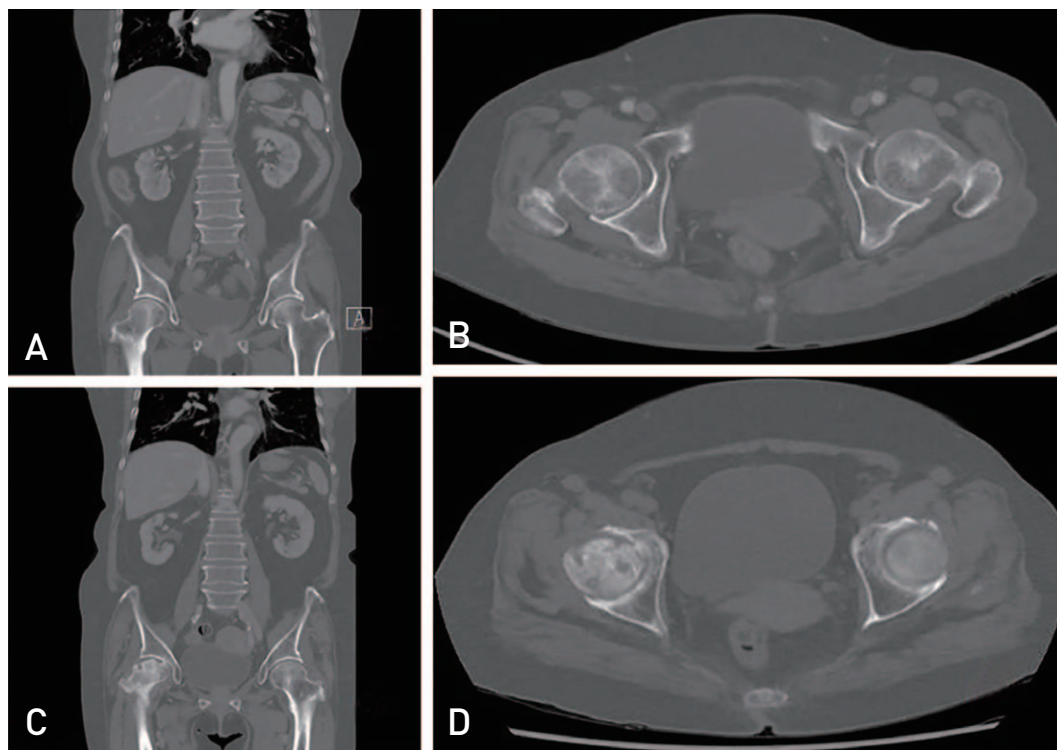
Initial computed tomography (CT) images are intact; (A) coronal image, (B) axial image. After 8 months, CT images show that femoral head collapse and subchondral bone cysts are formed (C) coronal image, (D) axial image.
